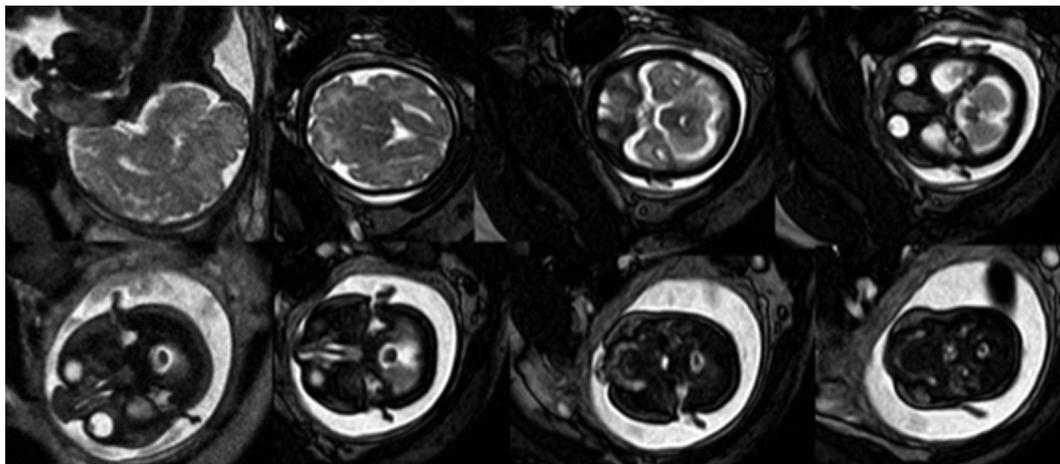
The intrauterine MRI for assessing the tumor and the fetal cranium.
